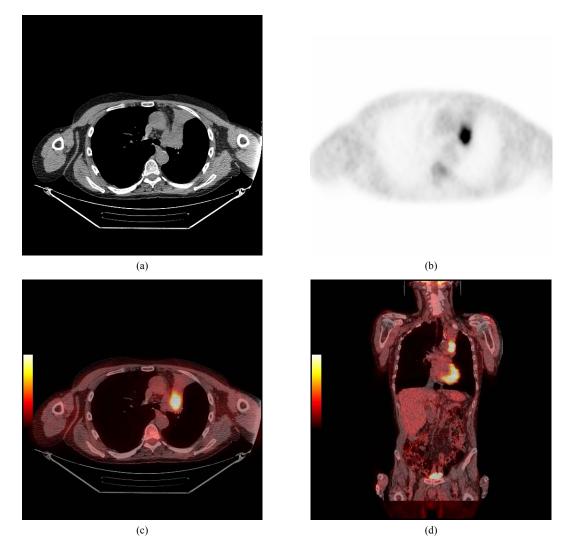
PET-CT Improves Target Volume Definition for Radical Radiotherapy. A series of CT, PET and fused CT-PET images of a left upper lobe primary NSCLC. a) Axial CT image, this highlights the difficulty in differentiating tumour from atelectasis and/or collapse/consolidation of normal lung. b) Axial PET image shows area of intense ¹⁸FDG uptake corresponding to tumour but the image lacks anatomical definition. c) Axial PET-CT fusion image clearly improves the clinicians ability to localise tumour for purposes of GTV definition. d) Coronal PET-CT image of the same tumour.
